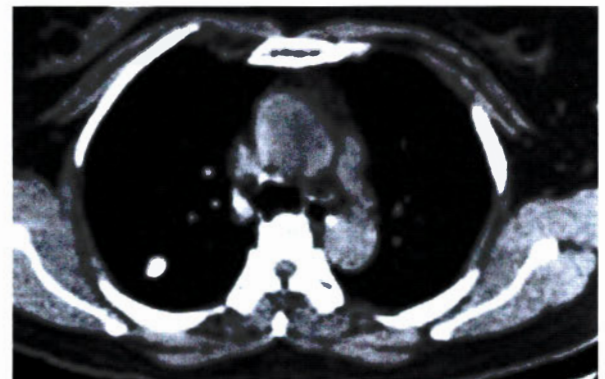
CT Chest: calcified pulmonary nodule
